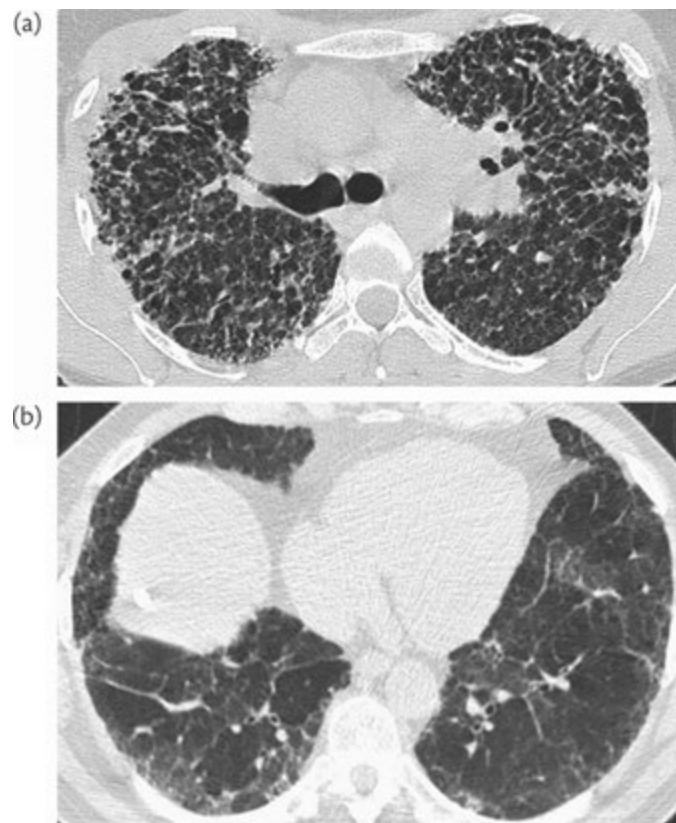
(a and b) HRCT scans in patients with biopsy-proven IPF, but in both cases the HRCT appearances are markedly atypical, with no features indicative of IPF or of any other form idiopathic interstitial pneumonia. IPF should always be suspected when disease is inexorably progressive and HRCT appearances are difficult to classify.
